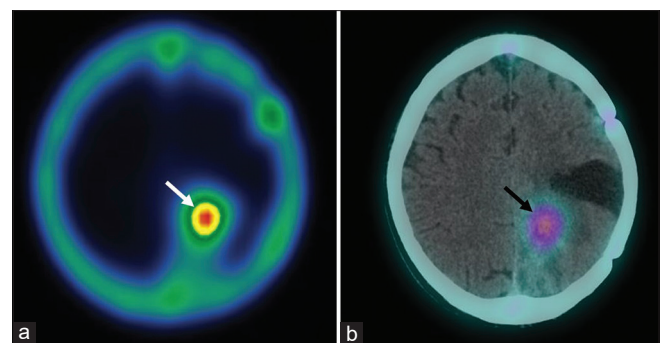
Tc-99m glucohepatonate single-photon emission computed tomography done after 1 week of magnetic resonance-positron emission tomography. Single-photon emission computed tomography image (a) and fused single-photon emission computed tomography/computed tomography (b) acquired post-Tc-99m glucohepatonate injection showing uptake corresponding to the areas of enhancement on magnetic resonance imaging (white arrow in a and black arrow in b). Note that the areas of gyral uptake seen on positron emission tomography images are no longer appreciated
